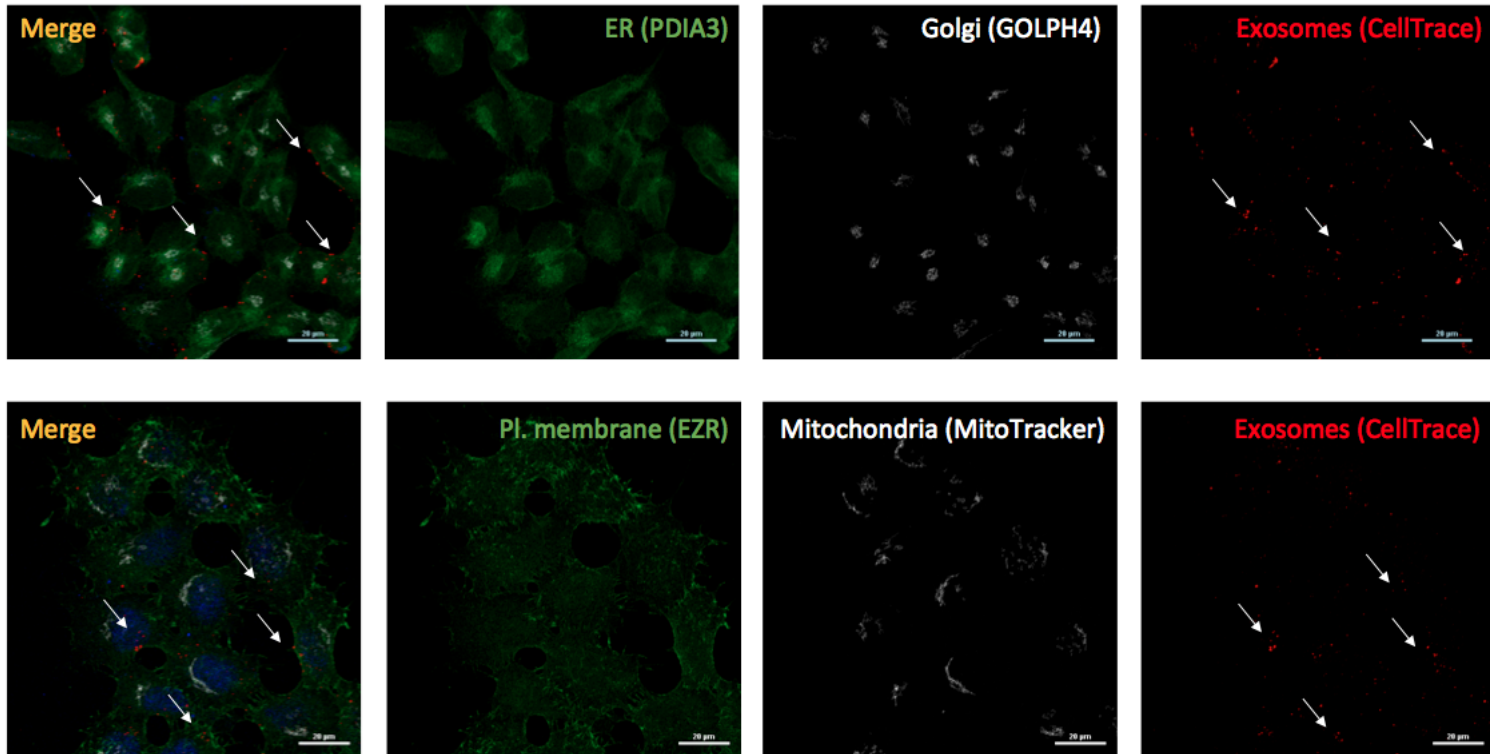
Biodistribution of exosomes inside recipient cells evaluated by IF. The localisation of labelled SK-N-MC exosomes (CT; red) after 4 h incubation with SK-N-MC cells was assessed. (Top) SK-N-MC cells labelled for endoplasmic reticulum (ER; anti-PDIA3, green), Golgi apparatus (anti-GOLPH4, white); (Bottom) or plasma membrane (anti-EZR, green) and mitochondria (MitoTracker, white). Arrows indicate exosomes clusters in merged image and red field. Nucleus (DAPI, blue). Scale bar = 20 μm .
